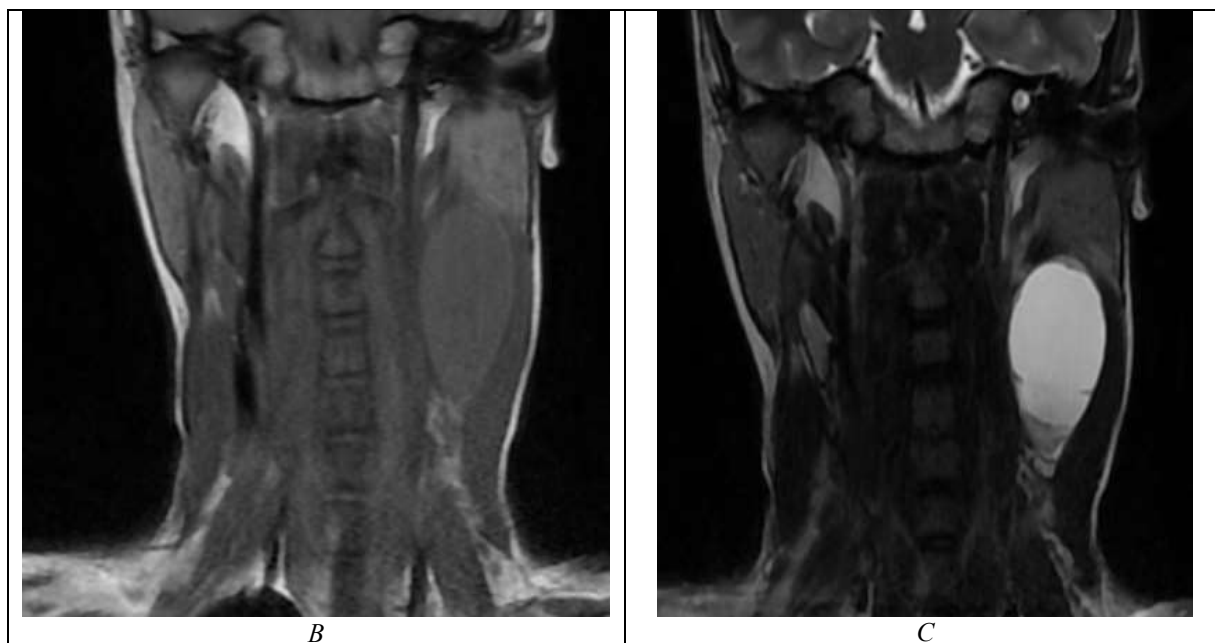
Figure B (on left): MRI T1 image shows a well defined Iso-intense lesion in the left upper deep cervical region
